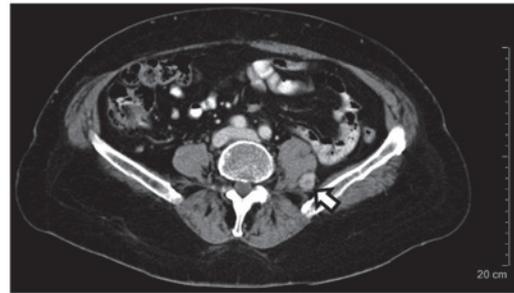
A new metastatic lesion from renal cell carcinoma in the left psoas major muscle (arrow) was identified on a follow-up computed tomography scan performed 2 years after chemoradiotherapy for lymphoma.
